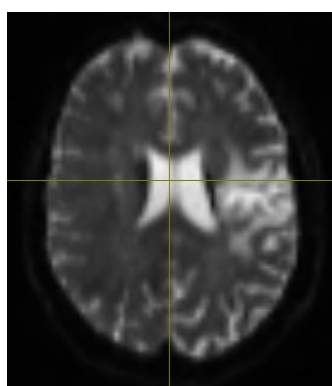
DWI stroke MRI image.
